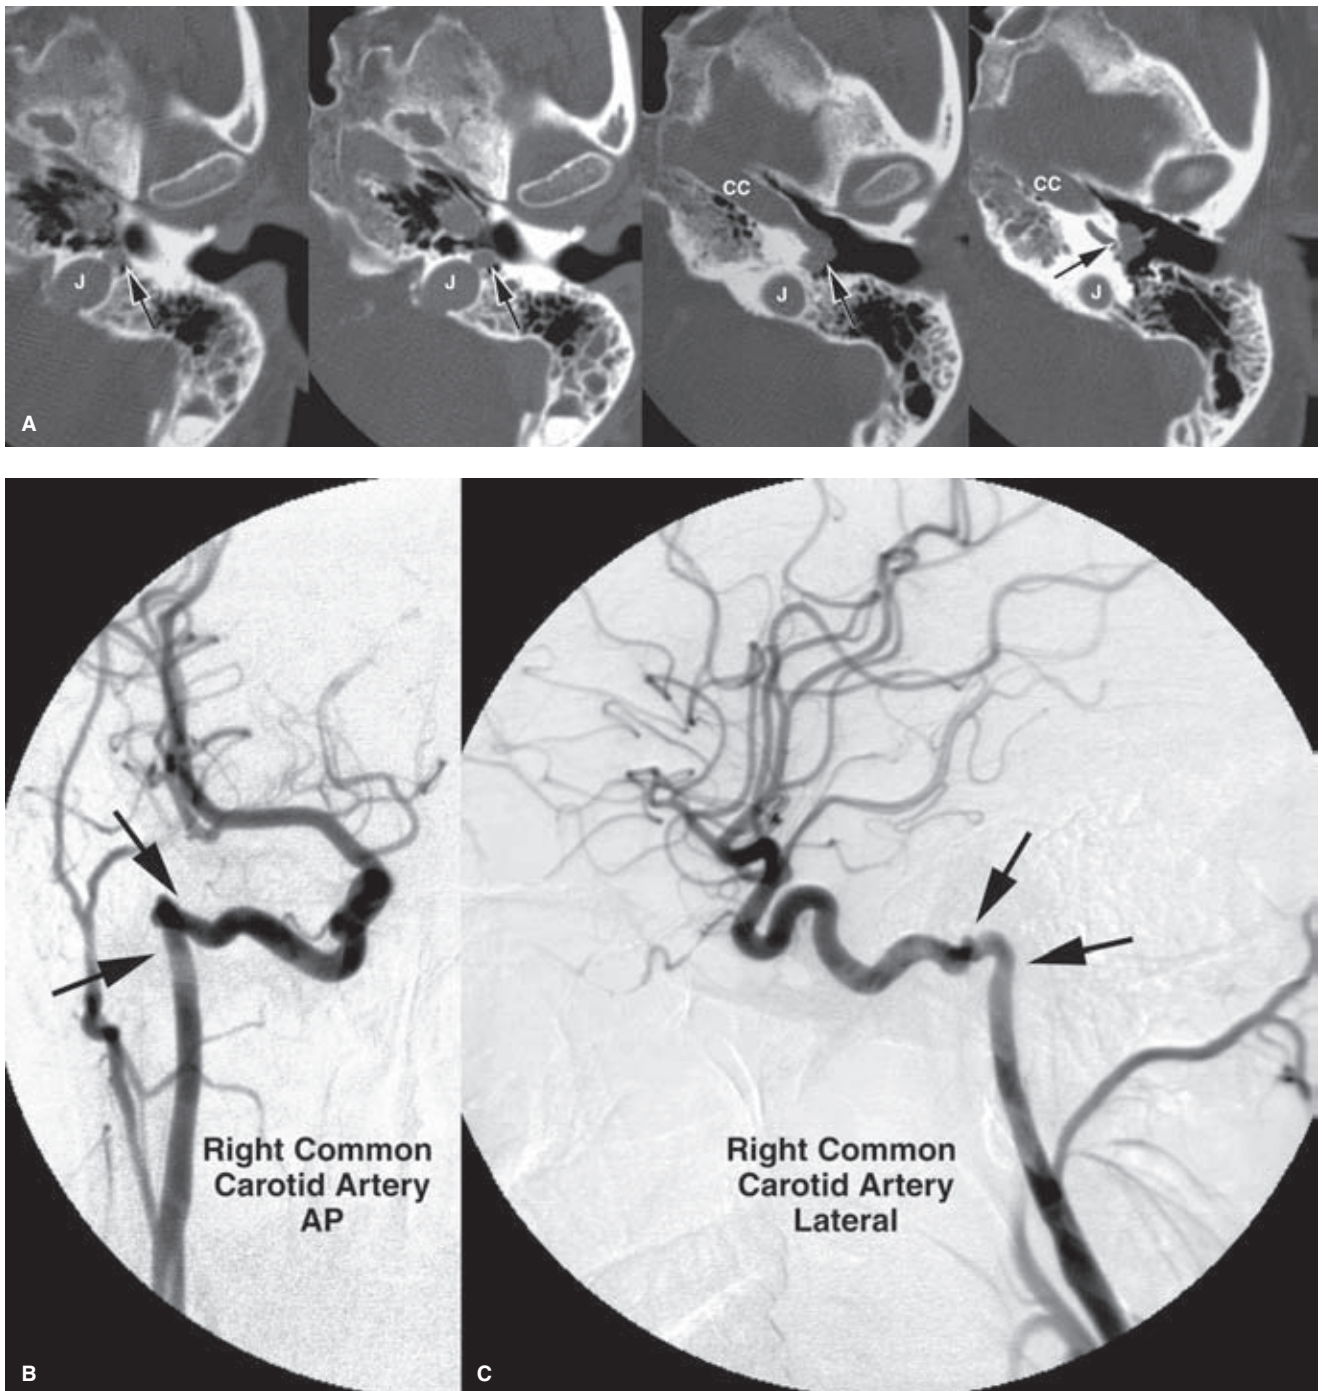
(A–C) Aberrant internal carotid artery. An elderly female was studied for evaluation of otosclerosis. A diagnosis of middle ear mass was reached. The “mass” was biopsied with a 22G needle, causing profuse bleeding. Axial CT images (A) from inferior to superior demonstrate absence of an exocranial ostium of the carotid canal (*CC*) in the usual location. An unusually large bony canal (*arrow*) is seen adjacent to the jugular bulb (*J*). Followed from one slice to the next, this canal becomes a tubular soft tissue structure joining the carotid canal (*CC*). At its apex in the middle ear, the afferent and efferent components of this vessel cannot be perceived on a single image explaining why this entity is sometimes misinterpreted as a mass. Notice how it lies lateral to the semicircular canals of the vestibular apparatus. This is a typical CT appearance of an aberrant internal carotid artery. Right common carotid arteriography demonstrates the typical angiographic appearance of an aberrant internal carotid artery. The artery extends more posteriorly than usual on the lateral view (C) with a constrained, knuckled appearance (*arrows*). On the AP view (B), it projects more laterally than does the usual course of the internal carotid artery. Fortunately, for this patient, a pseudoaneurysm at the biopsy site was not found.
